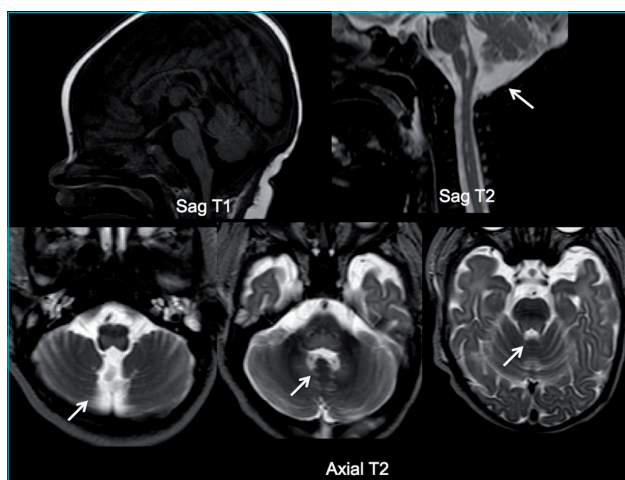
MRI: Sagittal T1, Sagittal T2 and Axial T2 views showing well-defined hypointense (T1) and hyperintense lesions (T2) at the dorsal portion of pons and bulb.
